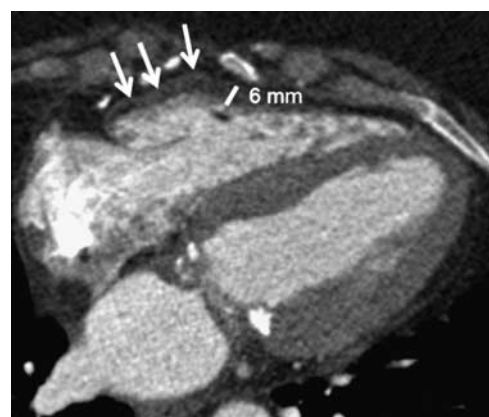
Non-ARVC/D fat infiltration in the RV wall on CT. Axial cardiac CT images in a 64-year-old woman being evaluated for tricuspid valve endocarditis. There is marked low-attenuation thickening of the wall of the RV secondary to fat infiltration up to 6 mm (arrows).
